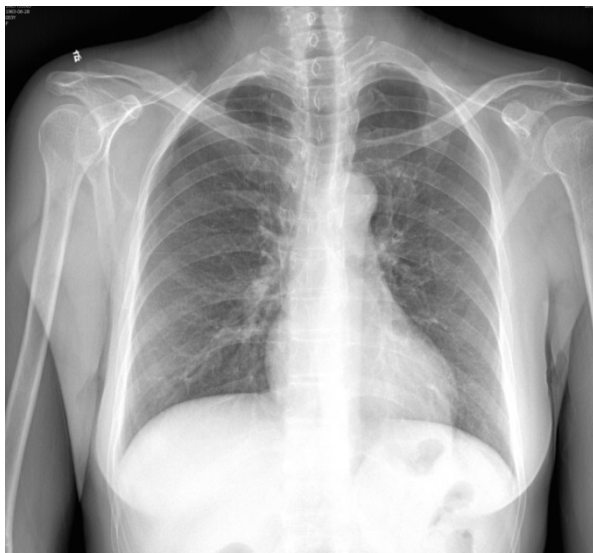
Chest X-ray film showed a normal size heart with clear lung markings.
